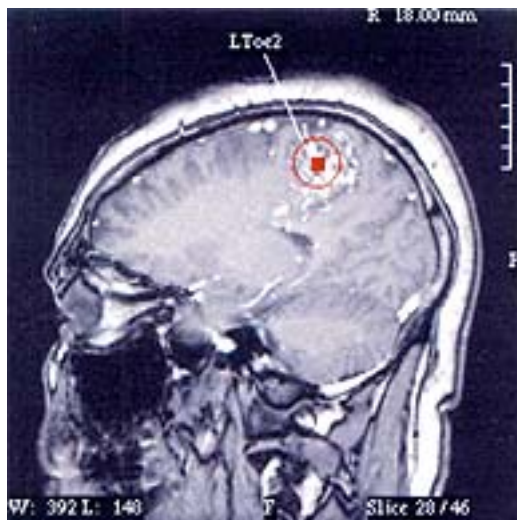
The MEG image reveals magnetic mapping points superimposed on the patient's  $T_1$ -weighted MR image. The indicated activity was derived from somatosensory stimulation of the left second toe and is marked as a *red square*. The surrounding *circle* represents a statistical confidence volume (closer to the square being greater confidence). The nidus straddles not only the anatomical central sulcus, but also the functionally defined one shown here, centered over the leg region. (Figure contributed by Howard A. Rowley, M.D., University of California San Francisco Medical Center.)
